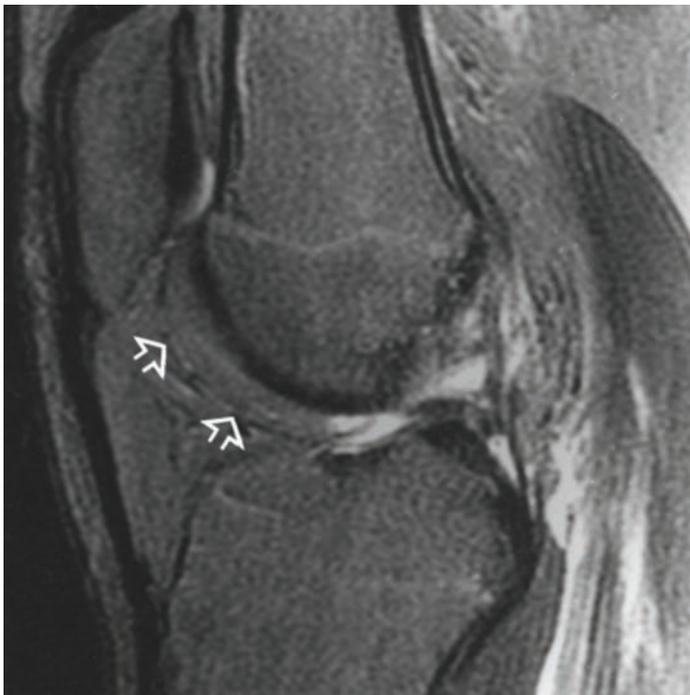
T2 weighted-MRI image of a normal patellar tendon demonstrating a homogenous band with relatively low signal intensity with clear distinction between the posterior border of the tendon and the underlying infrapatellar fat pad indicated by the arrows.
